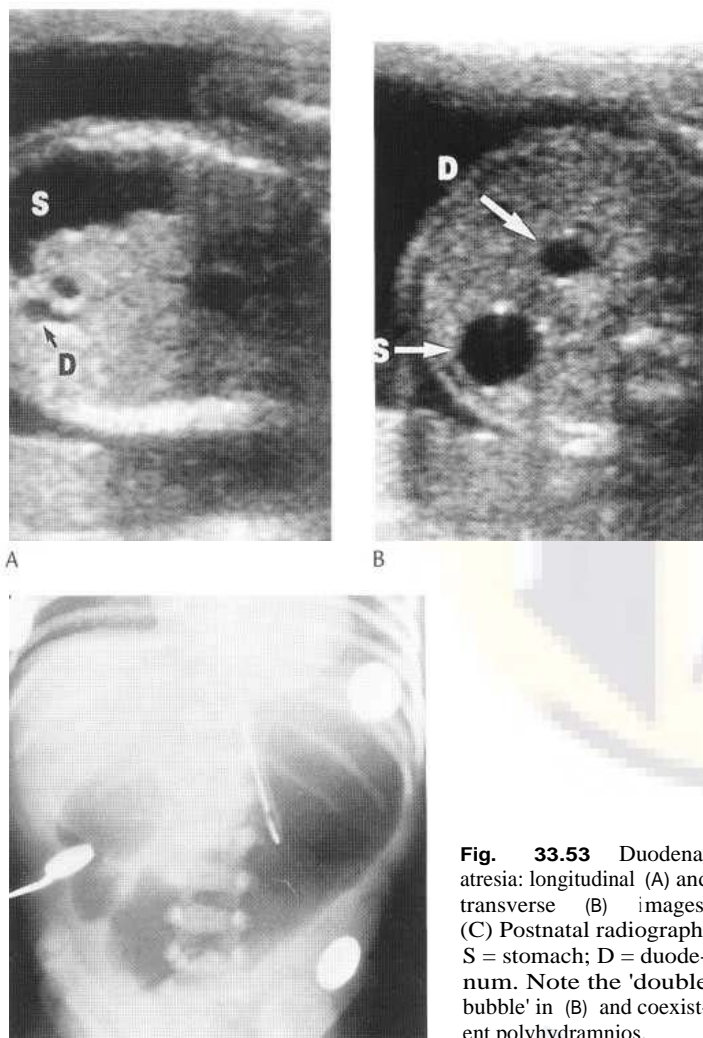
Duodenal atresia: longitudinal (A) and transverse (B) images. (C) Postnatal radiograph. S = stomach; D = duodenum. Note the 'double bubble' in (B) and coexistent polyhydramnios.
